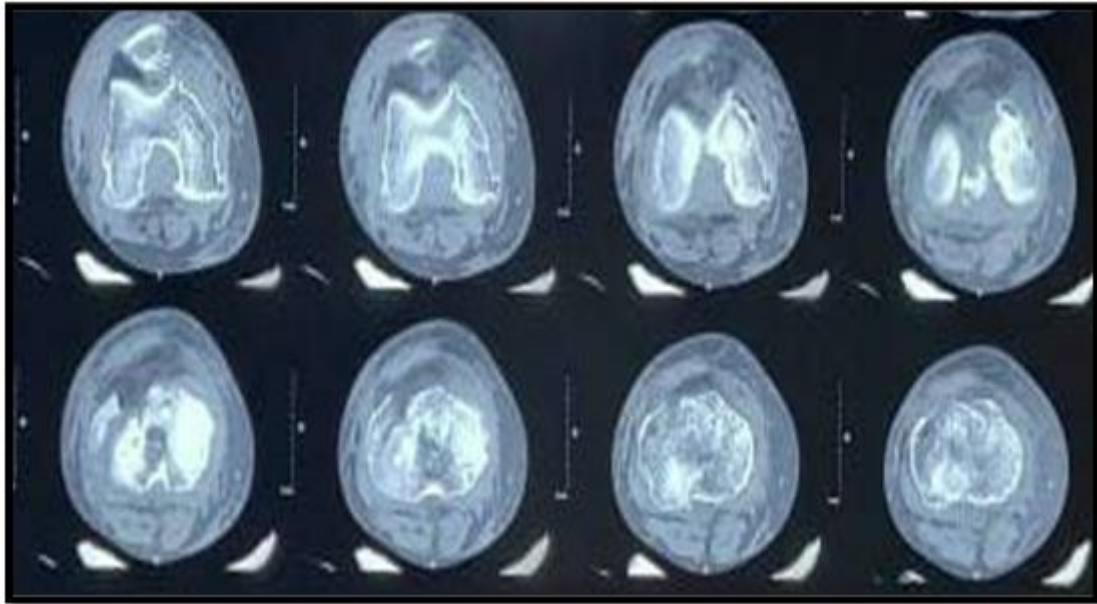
CT Scan Depicting Three Column Involvement
